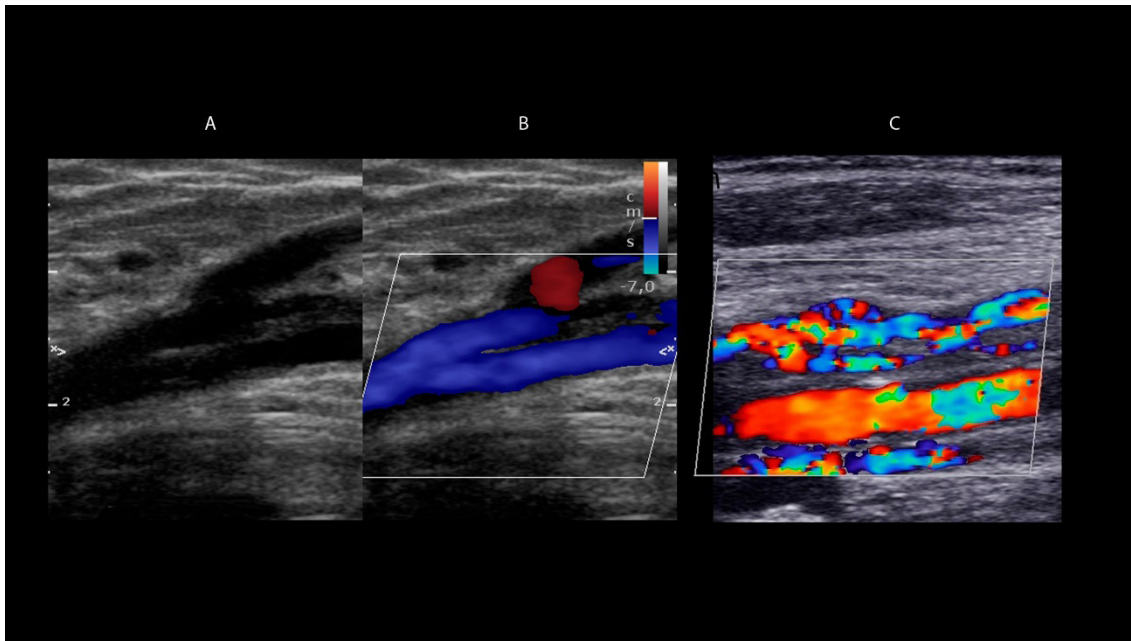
A: two-dimensional longitudinal image of the common femoral vein with parietal thickening and trabeculations/fibrous tissue inside the vessel. B: color flow Doppler showing flow around the trabeculation. C: similar findings in the popliteal vein.
